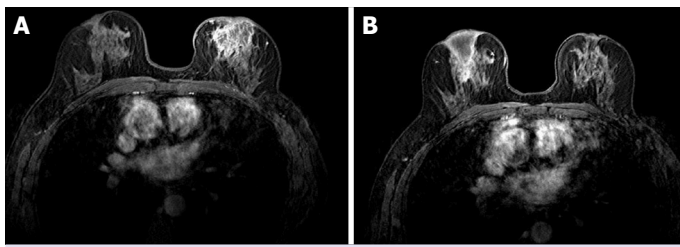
(A) A mass compatible with mastitis in the left breast on MRI before treatment. (B) While no lesion was observed in the left breast 18 months after the treatment, recurrence was detected in the right breast.
